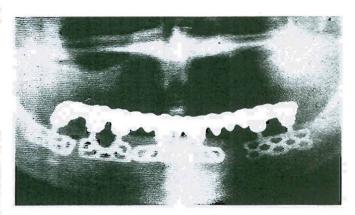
A panoramic radiograph of the completed case shown in Figs. 4 and 5.
